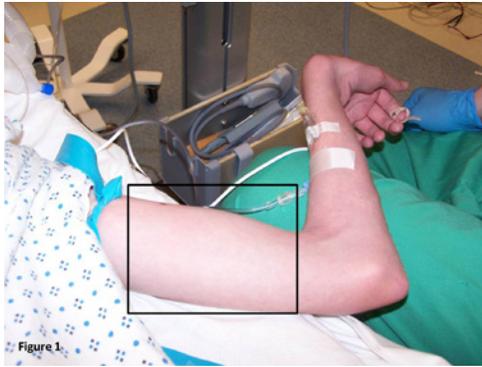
Upper extremity with tourniquet applied for ultrasound-guided peripheral vascular access. The region enclosed in the black box is the suggested starting point for ultrasound scanning to identify deep venous structures in the upper aspect of the arm.
